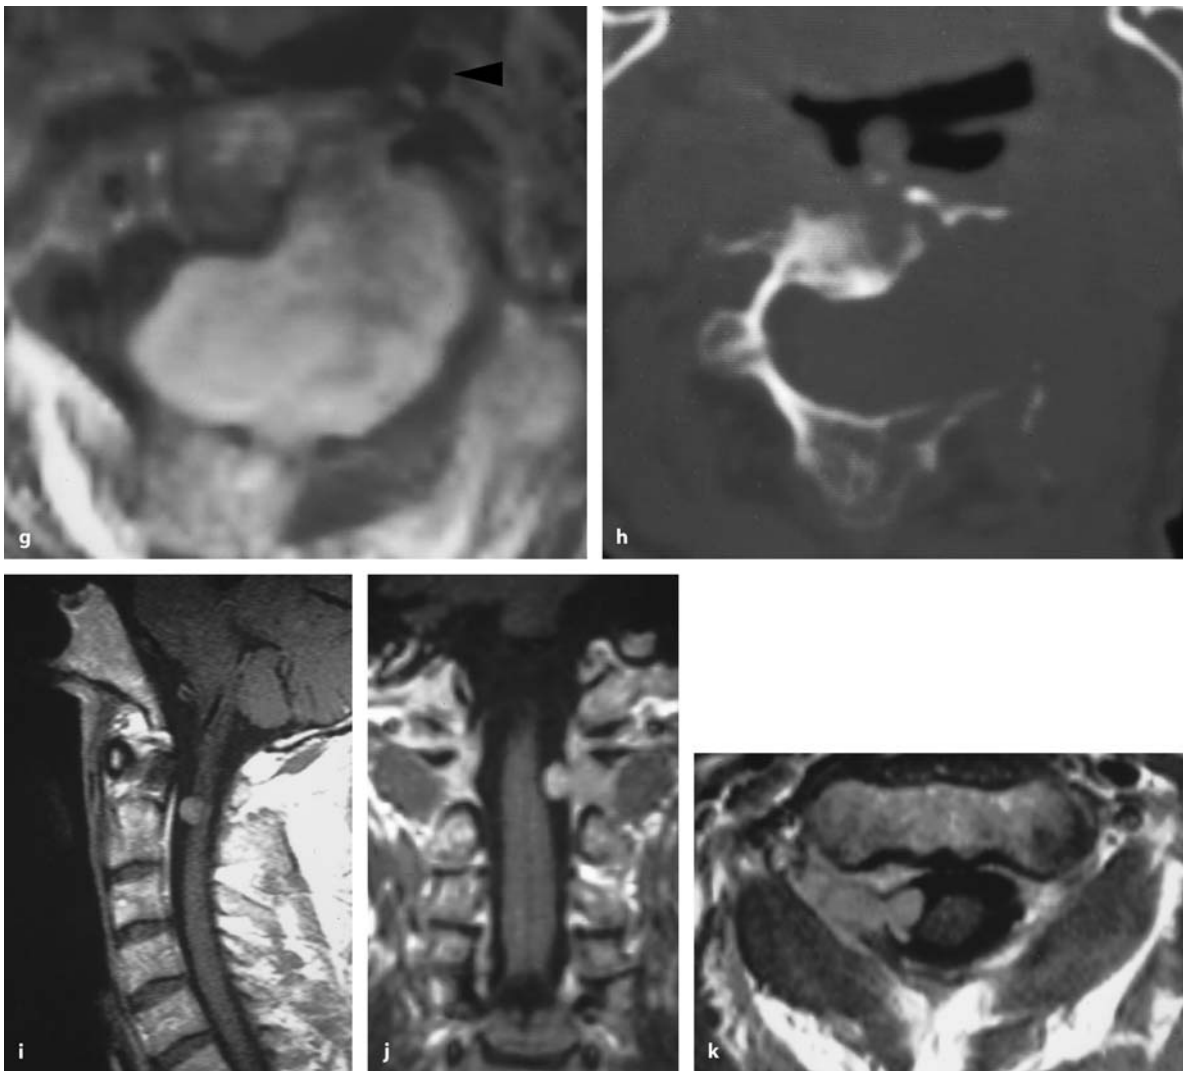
a Sagittal T2-weighted MRI of a posterolateral, calcified meningioma at Th10 in a 58-year-old man with an 18-month history of pain and slight gait ataxia. b The axial bone window computed tomography (CT) scan demonstrates the calcifications of this tumor
